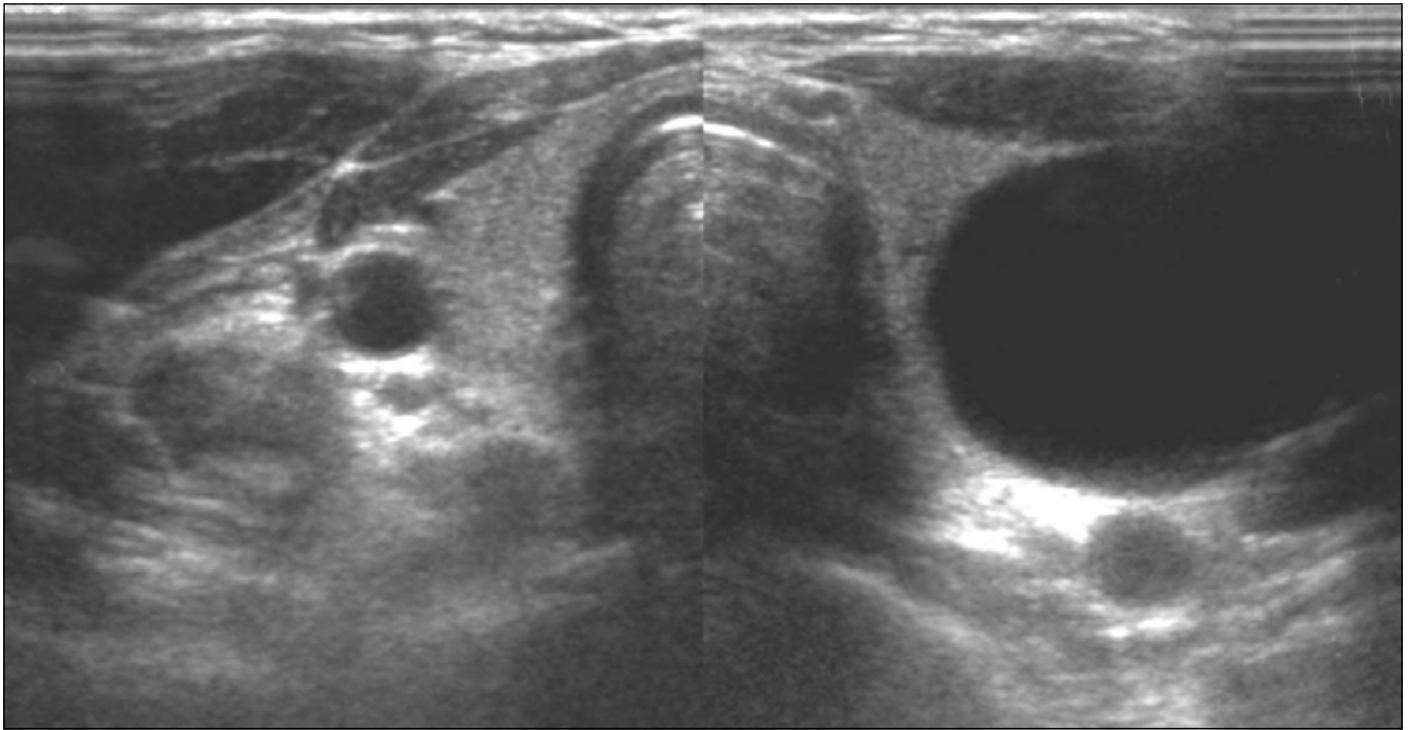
Ultrasound images comparing the right and left side of the neck. The large left-sided cystic lesion compressed surrounding structures and was thought to be thyroid in origin.
